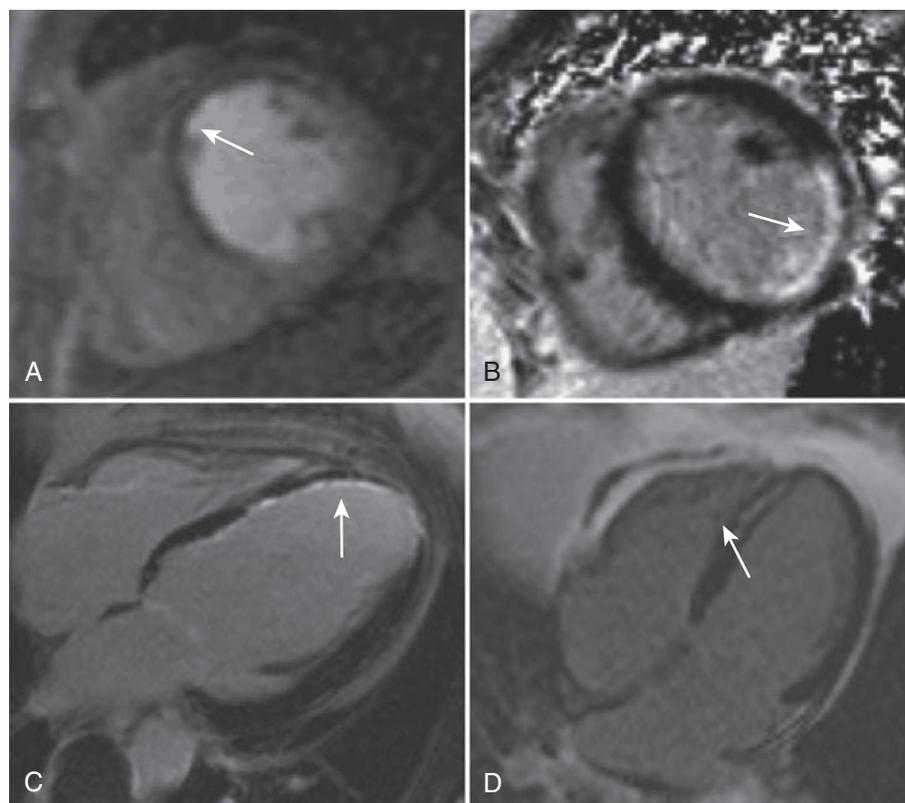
Use of cardiac magnetic resonance imaging in the evaluation of chest pain or ischemic heart disease. A, First-pass perfusion study during vasodilator stress shows a large septal perfusion defect (arrow). The hypoperfused area appears dark compared with the myocardium with normal perfusion. B, Example of delayed enhancement imaging of an almost transmural infarction of the mid-inferolateral wall, including the posterior papillary muscle. Infarcted myocardium appears white, whereas normal myocardium is black (arrow). C, Nontransmural (subendocardial) infarction of the septum and apex (arrow). D, Patient with acute myocarditis mimicking an acute coronary syndrome. Mid-myocardial, rather than subendocardial, delayed enhancement is characteristic of myocarditis (arrow).
